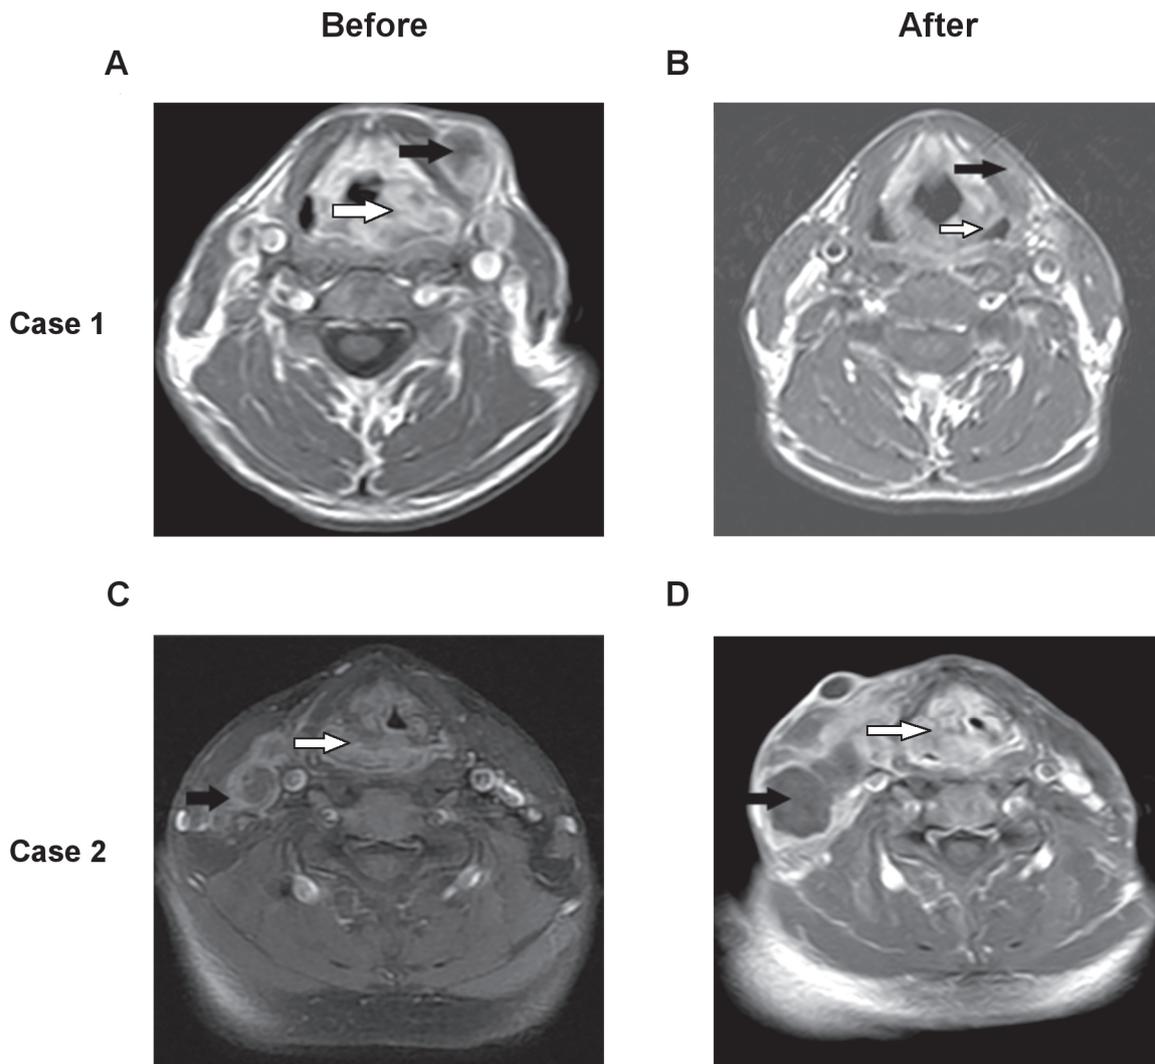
MRI scans were obtained before and after induction chemotherapy; images from two cases are shown. (A) Case 1: Before induction chemotherapy. The primary tumor is marked by a white arrow, and metastasis to a lymph node in the neck is marked by a black arrow. (B) Case 1: After induction chemotherapy. The primary tumor is marked by a white arrow, and metastasis to a lymph node in the neck is marked by a black arrow. Both, the primary and metastatic tumors were significantly reduced after induction chemotherapy. (C) Case 2: Before induction chemotherapy. The primary tumor is marked by a white arrow, and metastasis to a lymph node in the neck is marked by a black arrow. (D) Case 2: After induction chemotherapy. The primary tumor is marked by a white arrow, and metastasis to a lymph node in the neck is marked by a black arrow. Both, the primary and metastatic tumors had increased in size after induction chemotherapy.
